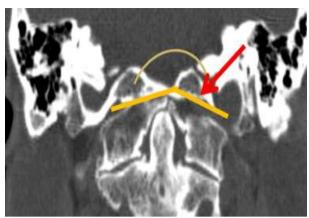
Flattened condyles. CT coronal section showing flattened occipital condyles (red arrow) and widening of atlanto-occipital joint axis angle (yellow line).
